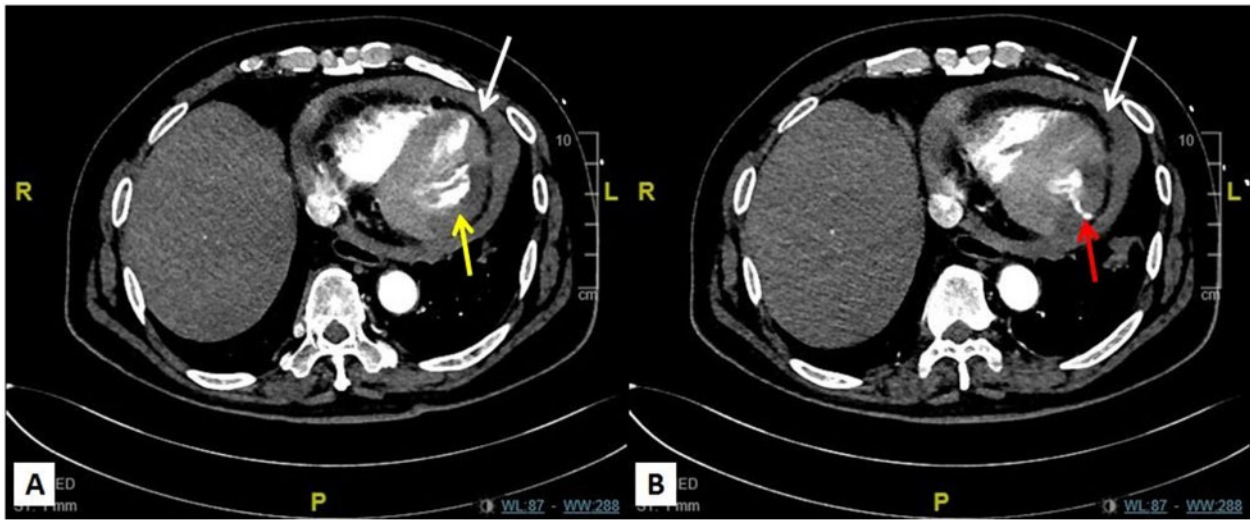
Computed tomography aortogram showing hypoenhancement of the posteroinferior wall of the left ventricle suggesting possible myocardial infarction (A, yellow arrow). There was a transmural linear track of contrast seen extending from the lumen to the left ventricular wall raising concern for possible perforation of left ventricular wall (B, red arrow). Moderate haemopericardium seen with mild compression of right ventricle in keeping with cardiac tamponade (white arrow).
